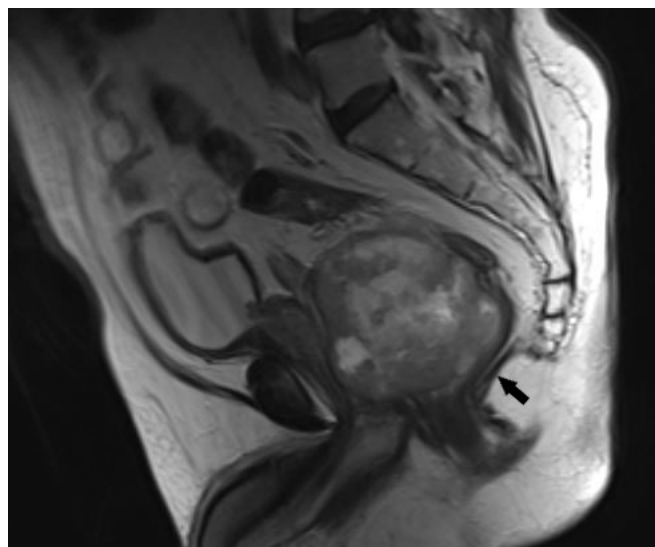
Sagittal T2-weighted MRI sequence showing bulky GIST (arrow) involving anterior wall of rectum
